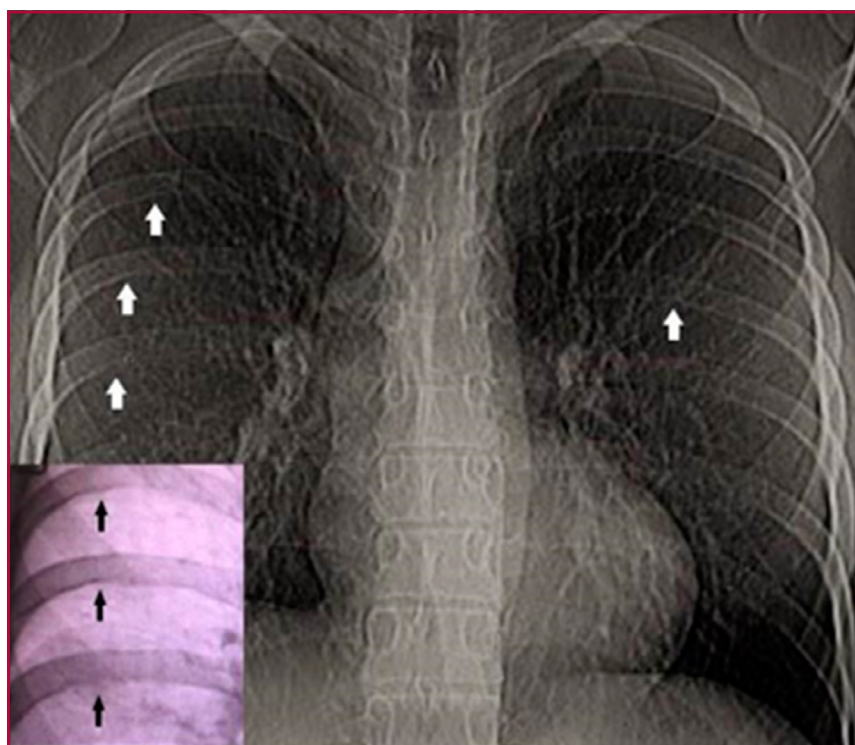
Chest X-Ray: Bilateral rib notches (Roesler's sign)
